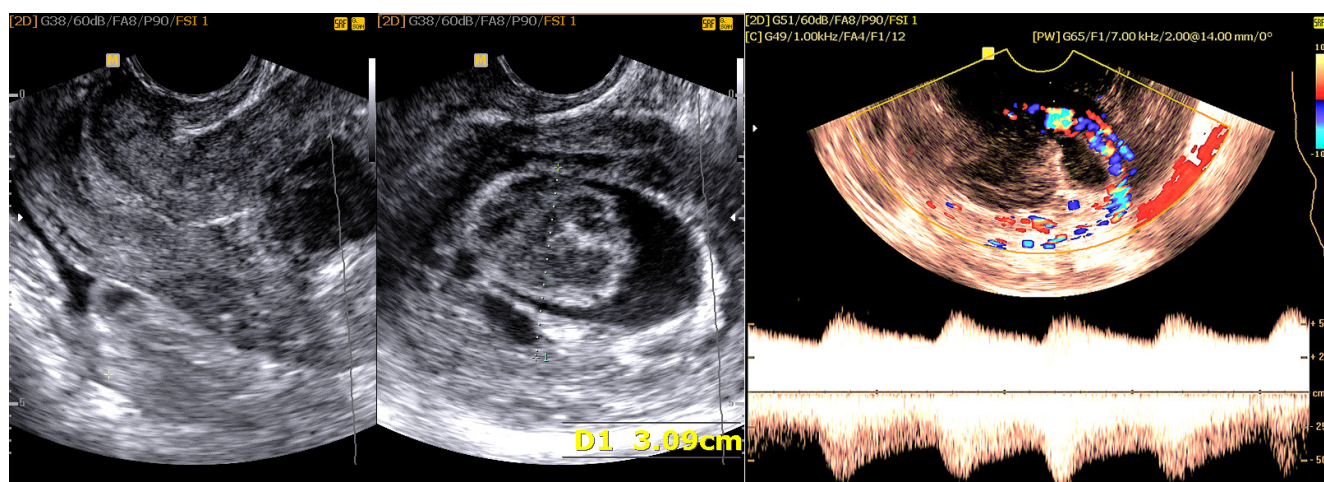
Transvaginal CD sonography examination of a case with postpartum hemorrhage showing large mobile and compressible blood clot of heterogeneous texture within the endometrial cavity associated with hypervascularity of the inner myometrium at the implantation site suggesting subinvolvement of placental implantation site
